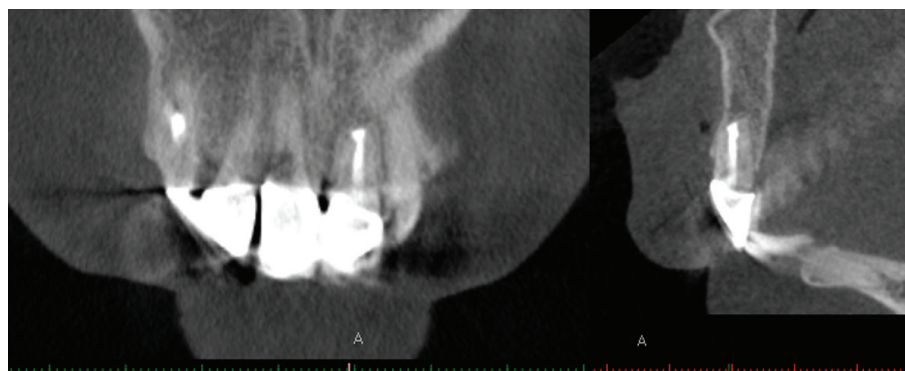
A 24-month follow-up CBCT scan showed the healed periapical lesion and no sign of root resorption.
